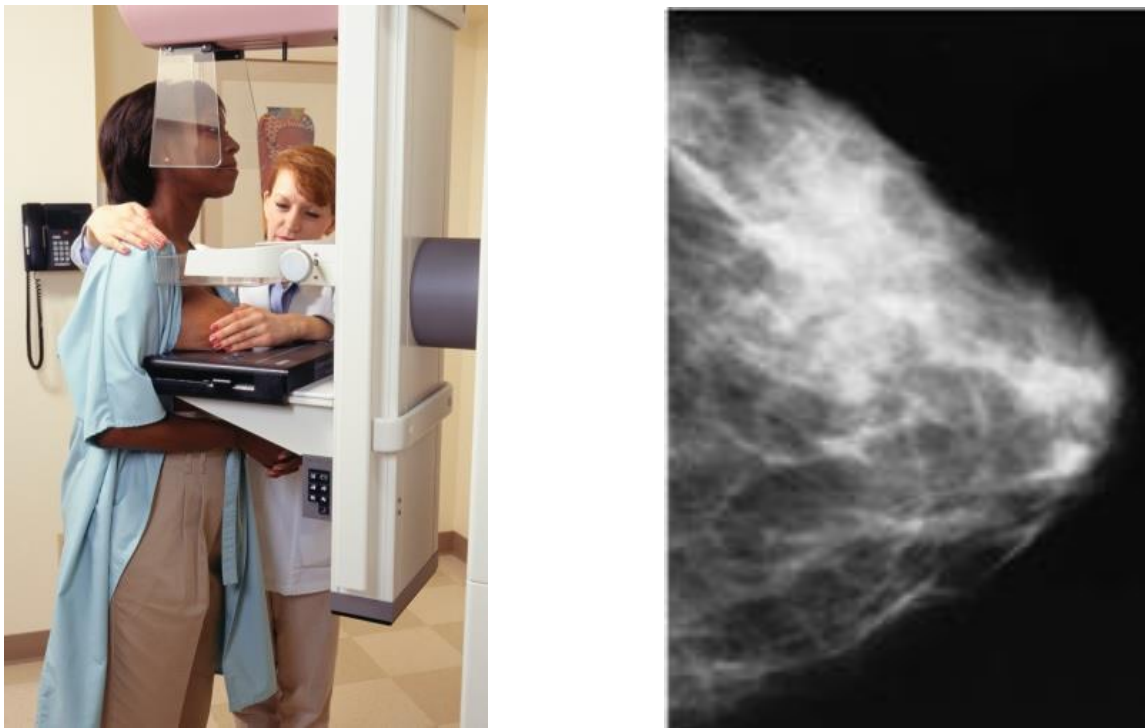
X-ray Mammography (left) and Output Image (right) (CDC, 2020). The breast is flattened, often uncomfortably, and photographed using X-Rays. The output image shows a 2D representation of the 3D tissue density distribution within the breast.
